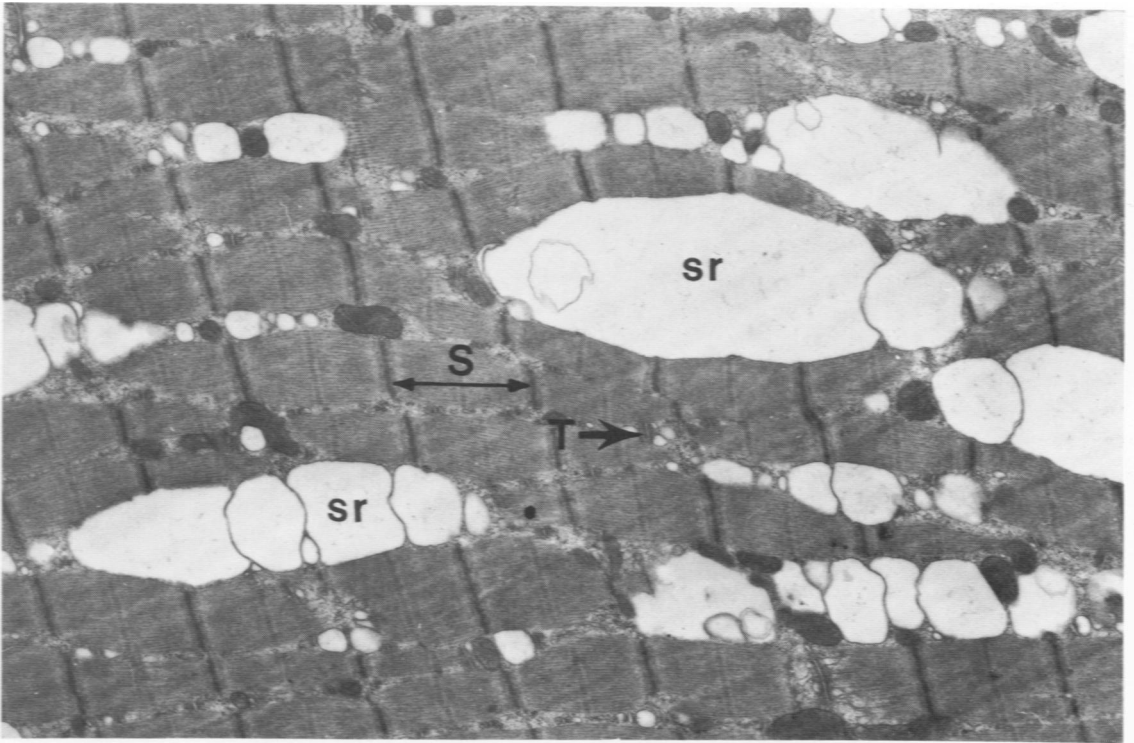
Muscle 3 hours postinjection. Note dilatation of sarcoplasmic reticulum (arrows). Sarcomeres (S) and T tubules (T) are intact. ($\times 9000$) Figure 7—Muscle 12 hours postinjection. M = muscle fiber, N = nucleus of muscle cell, CT = connective tissue cell, En = endothelial cell of capillary, Er = erythrocyte. Note dilated perinuclear space (dp) and dilated sarcoplasmic reticulum (sr). Connective tissue cell, capillary and erythrocyte are all structurally intact. ($\times 8500$)
